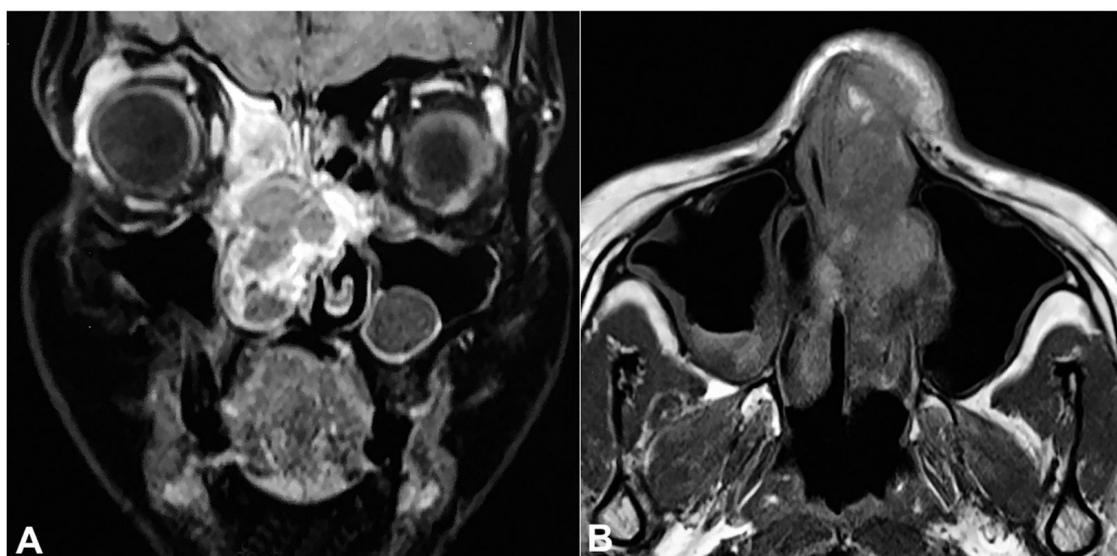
Fascial MRI – A – coronal view of T1 weighted image showing lobulated polypoidal lesion arising from the nasal septum measuring 4.5 X 3 cm causing occlusion of the right nasal cavity with erosion of nasal septum and ethmoidal air cells; B – Axial view of T1 weighted image showing polypoidal lesion in the right nasal septum.
